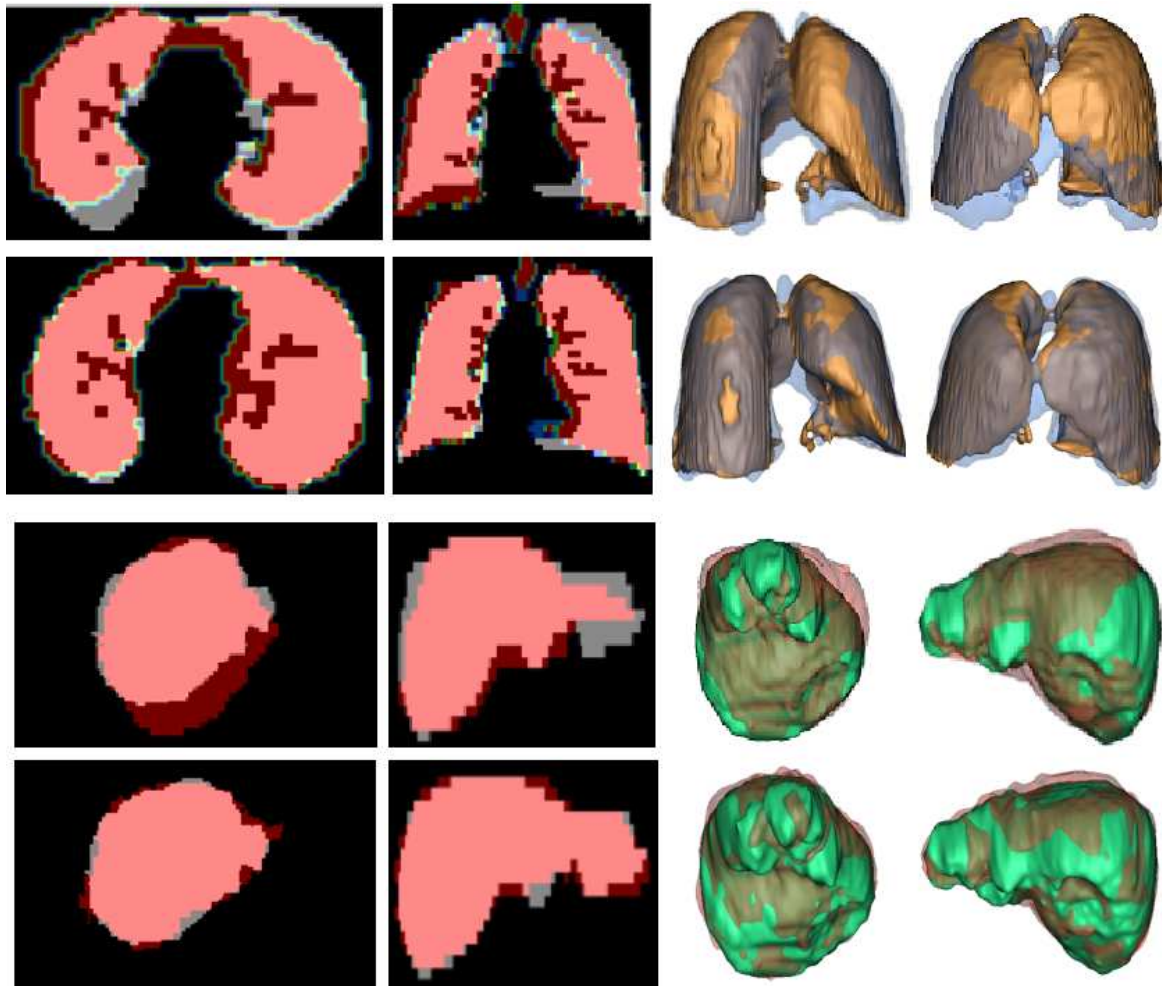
Structure registration results obtained with the GVF-FFD method. Left part of the figure: 2D coronal and axial slices of CT (grey) segmented lungs (top rows) and liver (bottom rows) are superimposed on their homologous PET structures (red), registered with a linear transformation (first and third row) and with the GVF-FFD method (second and fourth row). Right part of the figure: a 3D representation of the same structures is shown (CT lungs in blue, registered PET lungs in brown, CT liver in green and registered PET liver in red).
